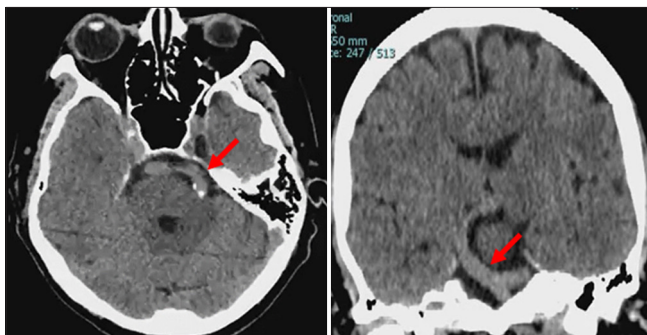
Non-contrast head computed tomography scan showed atherosclerosis with dolichoectasia of the basilar artery (red arrows).
